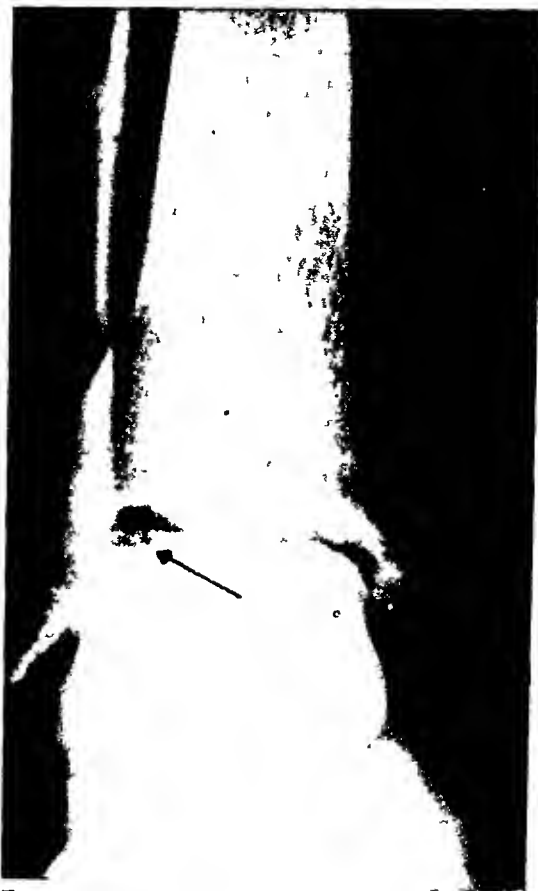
Case II. Roentgenogram of right ankle showing osteochondritis dissecans involving the superior articular surface of the right talus.
